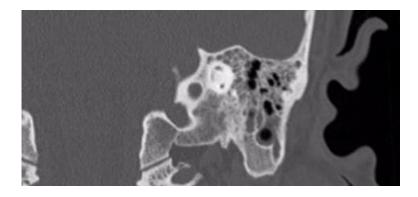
CT scan of the left internal auditory canal - coronal view
